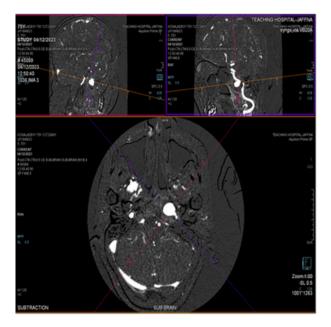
CT angiogram showing left ICA pseudoaneurysm in C3 segment
